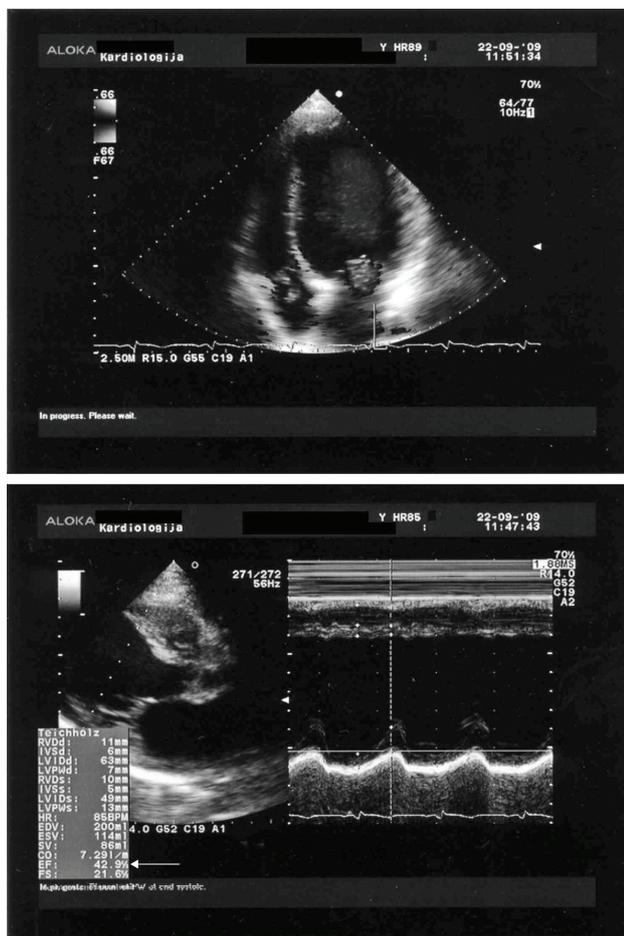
Case 1: Transthoracic echocardiograph (TTE) showing thin interventricular septum with anteroapicoseptal aneurysm. Ejection fraction of left ventricle (EF LV) is 41%.
